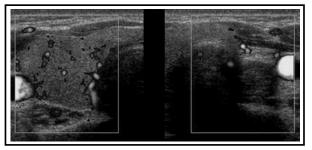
On Doppler US, vascular structures are not evident in the left side.
